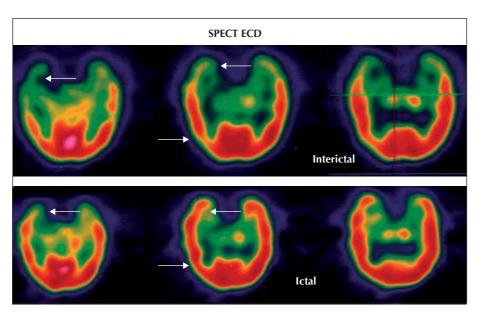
Interictal and ictal SPECT.
